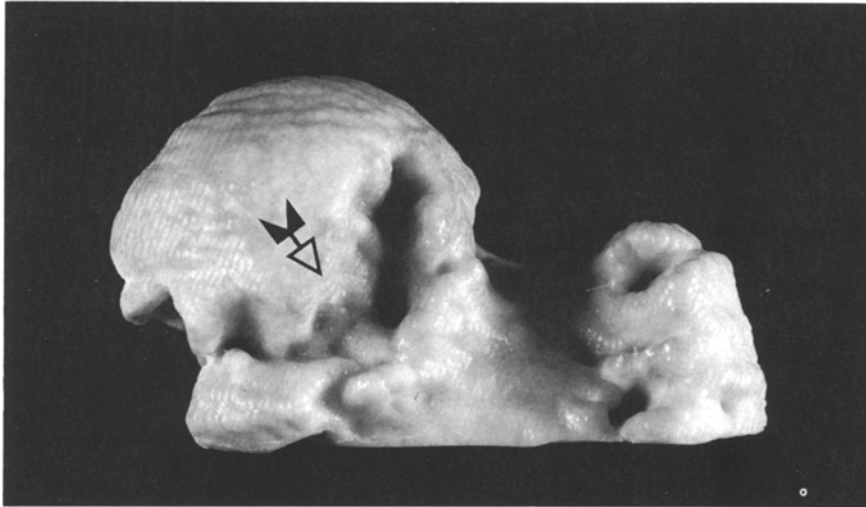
Post-traumatic deformities of the femoral head. Polyethylene model of the proximal femur constructed from axially-derived CT data reveals a prominent cleft (*arrow*) near the head-neck junction related to a previous injury which correlated well with findings at surgery
